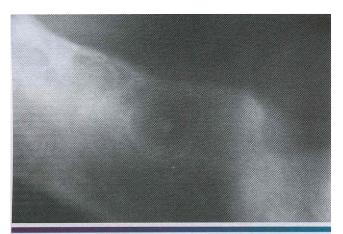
• Residual periapical cyst. Radiolucency with central radiopacity of the right mandibular body.
